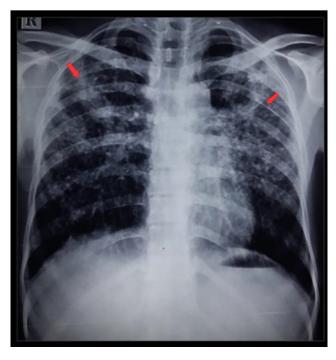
Chest X-ray showing bilateral upper andmidzones Micronodules (left &; right)
